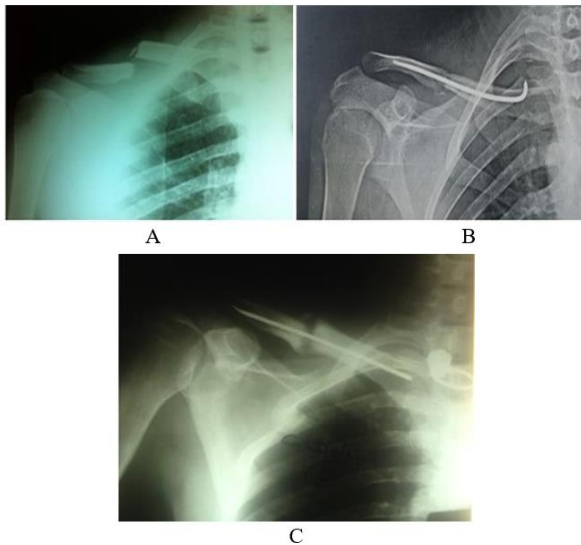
showed that A) Preoperative x-ray, B) Postoperative x-ray & C) X-ray after six months
